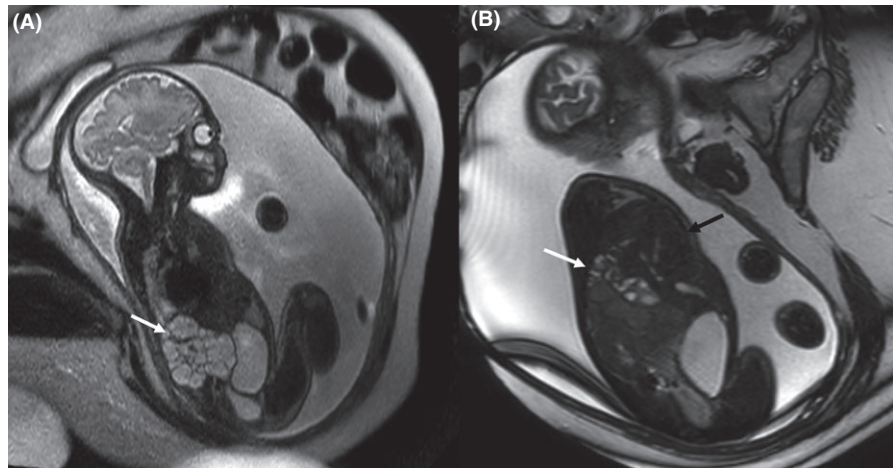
Magnetic resonance imaging at 33 weeks of gestation, sagittal views of the fetus. A, Left polycystic dysplastic kidney (arrow). B, Right-sided CDH with herniation of parts of the small intestine (white arrow) and the liver (black arrow) into the thorax
